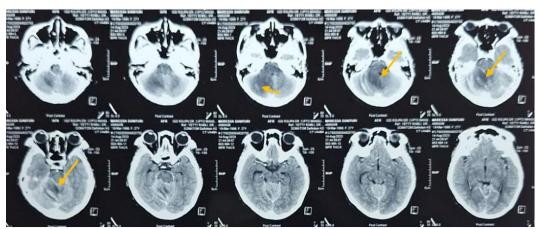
CT scans axial cut shows vasogenic edema with enhancement of leptomeninge
